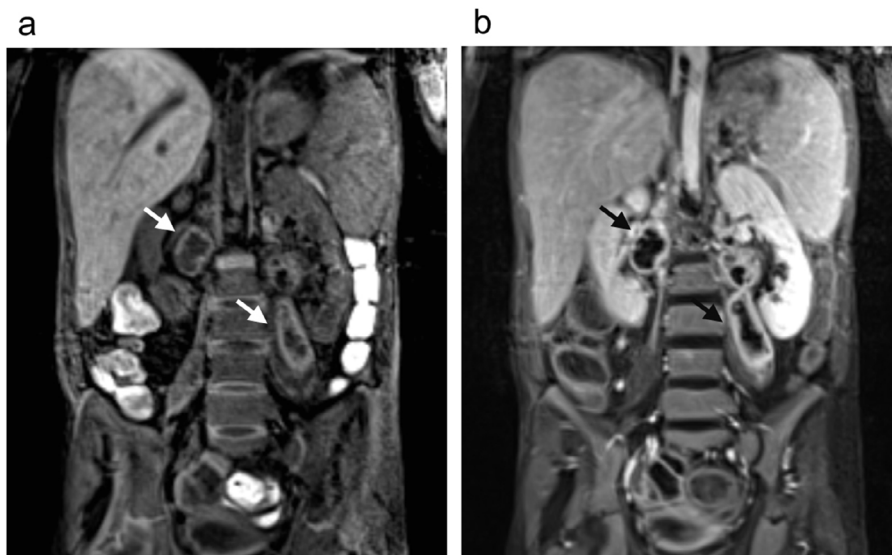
Magnetic resonance imaging of the abdomen before (a) and after (b) intravenous gadolinium contrast injection. The larger abscess formations are indicated with arrows.
